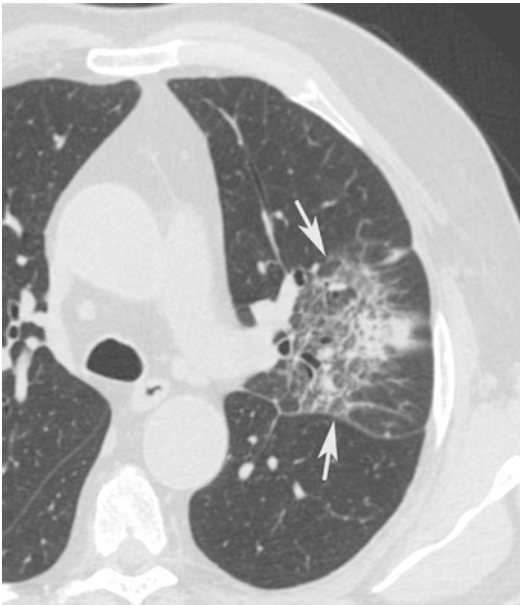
Interstitial pneumonia. CT axial scan evidences that the lingular interstitial septa, bronchial and bronchiolar walls are thickened for an inflammation process (*arrows*). There is also a central lobular consolidation with patchy appearance
